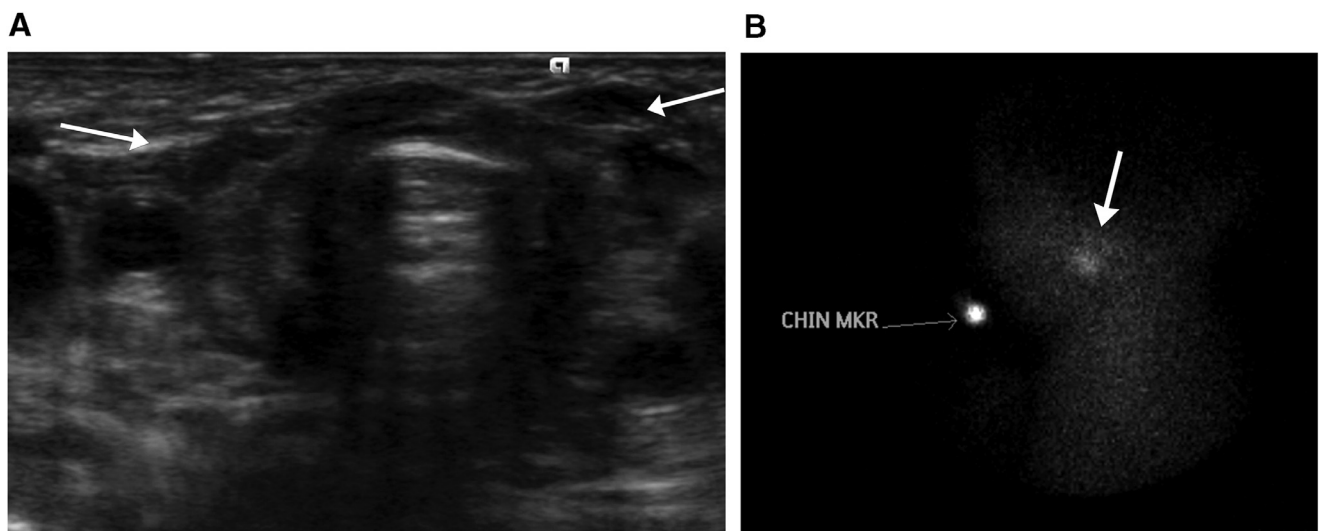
Ectopic thyroid misdiagnosed as thyroid agenesis by ultrasound. Four-day-old girl with abnormal congenital blood spot screening. A. Transverse gray scale ultrasound image of the anterior neck failed to show the thyroid on its usual position wrapping around the anterior aspect of the trachea (arrows). B. Tc99m pertechnetate scintigraphy performed 4 days later. Left lateral projection shows uptake at the inferior portion of the mouth posteriorly (arrow), in keeping with ectopic lingual thyroid.
